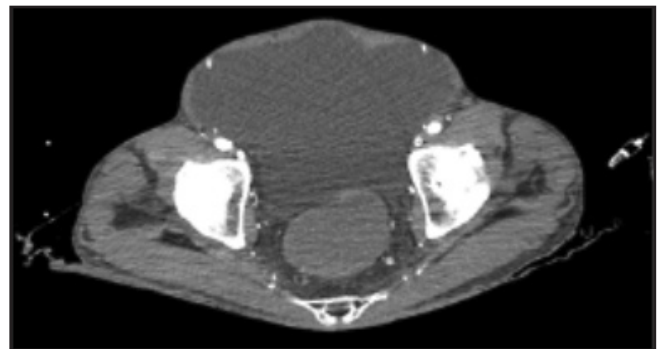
Arterial phase CTA demonstrating no active extravasation.
